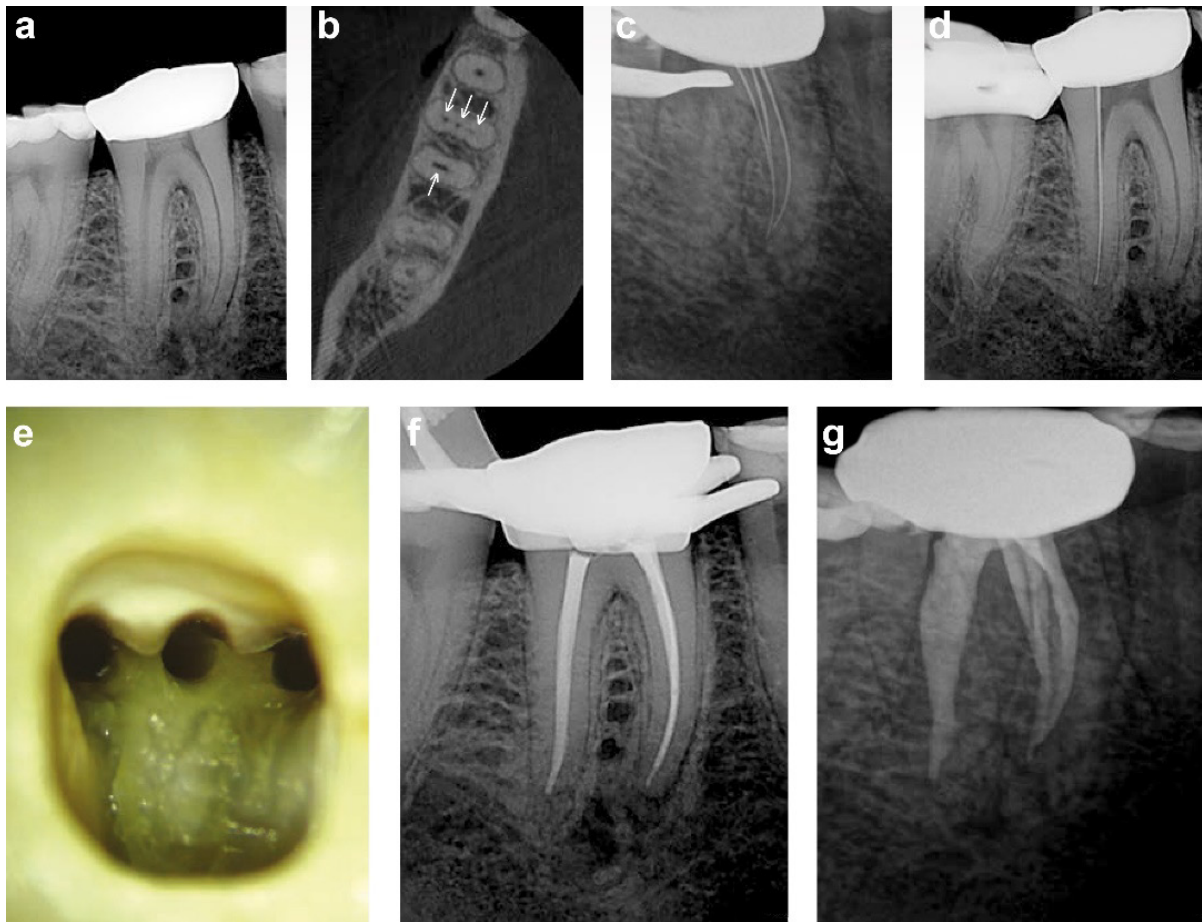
(a) Pre-operative periapical radiograph of mandibular right first molar; (b) An axial slice of a high resolution CBCT scan revealed four root canal systems (arrows). Three root canals in the mesial root and one large oval root canal in the distal root; (c) Periapical radiograph taken with a mesio-angulated view to confirm the length determination for the three mesial root canals; (d) Periapical radiograph to confirm the length determination for the distal root canal; (e) Magnified view of the pulp chamber floor. Note the large amount of tooth structure that was still intact after root canal preparation with the TruNatomy Small file; (f) Parallel view of the obturation result. Note the maximum preservation of the root structure in the peri-cervical region of the mesial and distal root canal systems; (g) Mesio-angulated view shows the full extend of the lateral anatomy that was cleaned and obturated.
